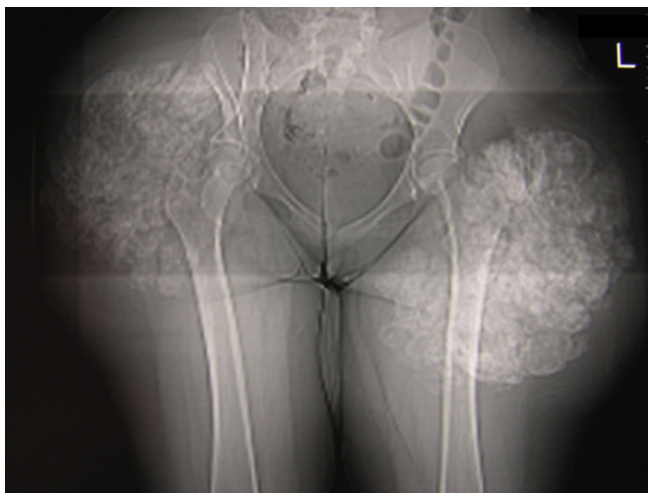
Plain pelvic radiography, showing bilateral calcified masses, around both hips.
